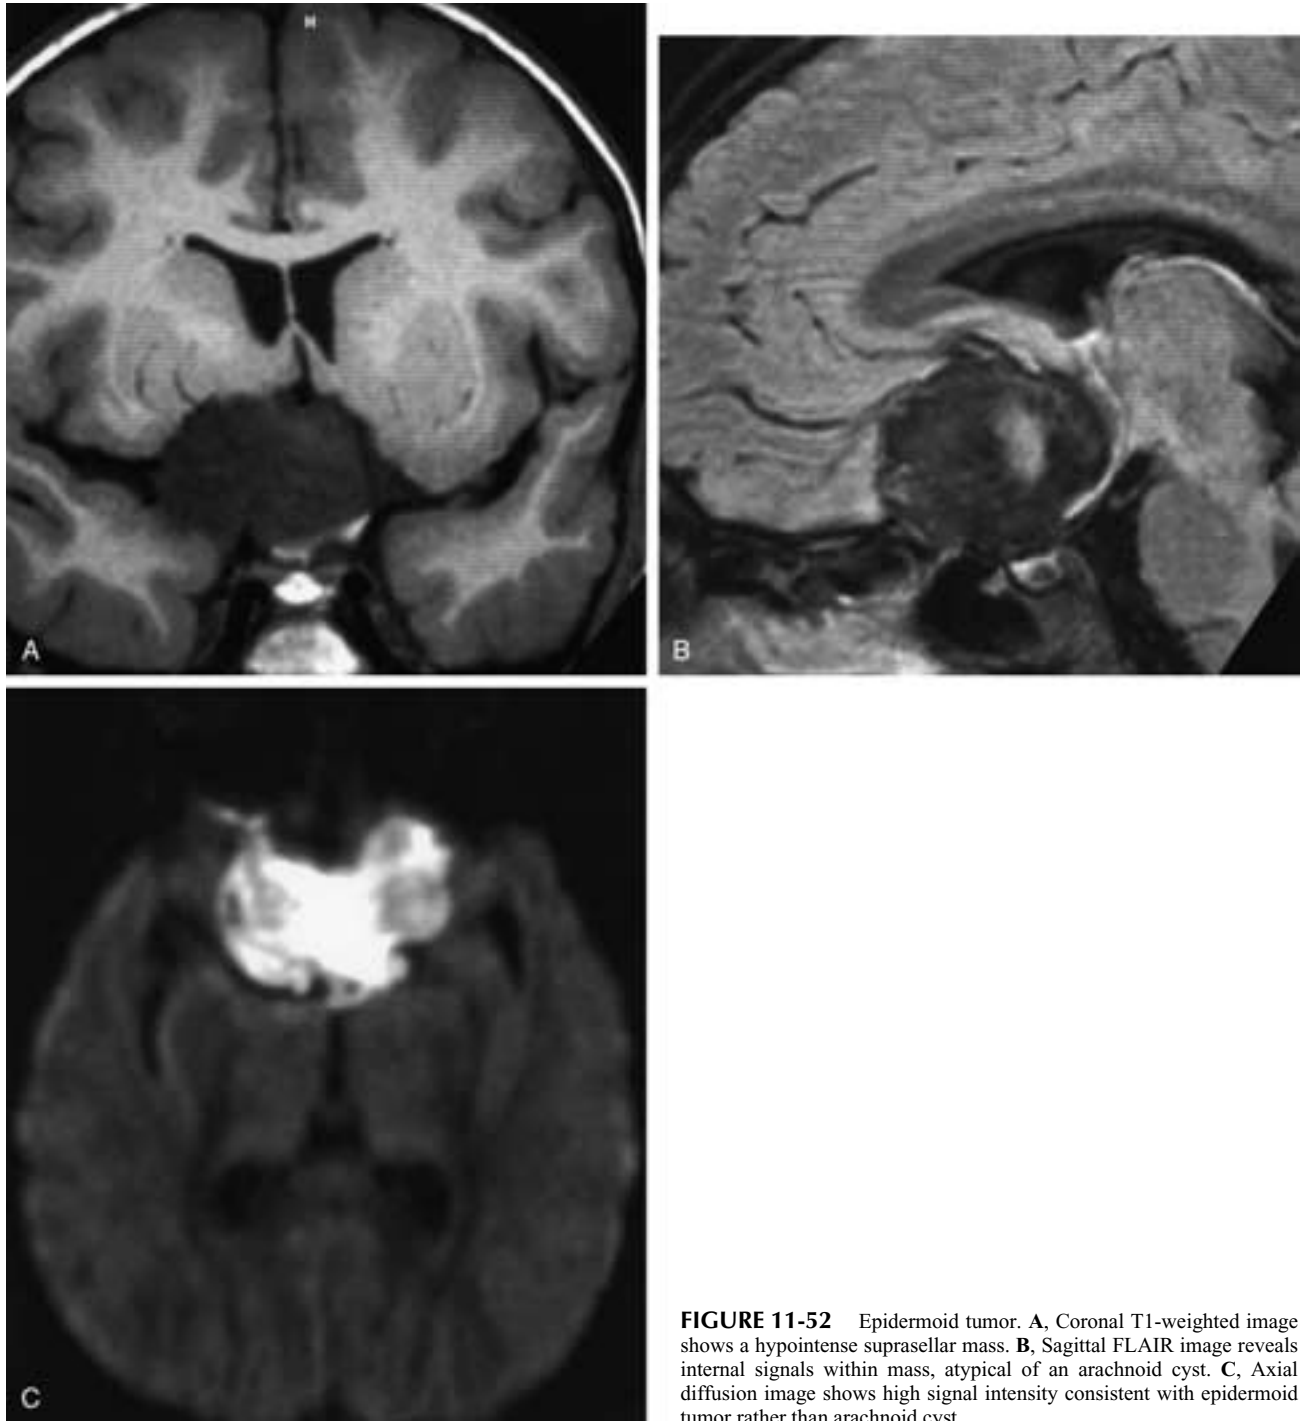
Epidermoid tumor. A, Coronal T1-weighted image shows a hypointense suprasellar mass. B, Sagittal FLAIR image reveals internal signals within mass, atypical of an arachnoid cyst. C, Axial diffusion image shows high signal intensity consistent with epidermoid tumor rather than arachnoid cyst.
